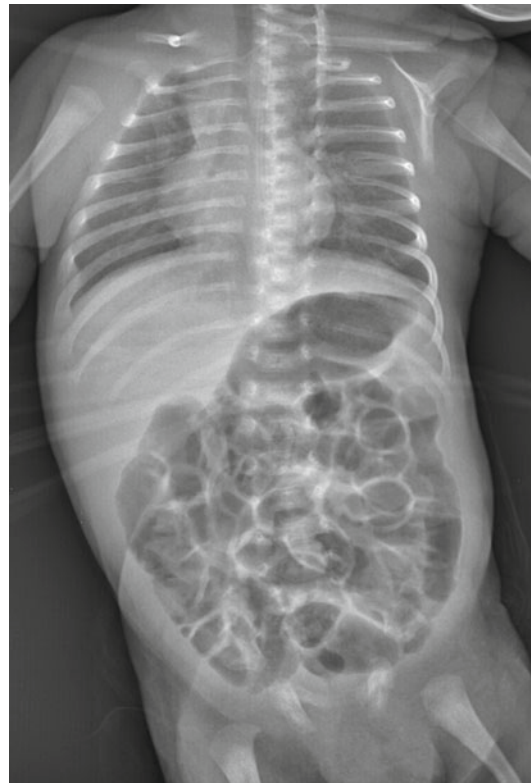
Abdominal plain film in newborn: normal “mosaic” aspect of neonatal bowel
